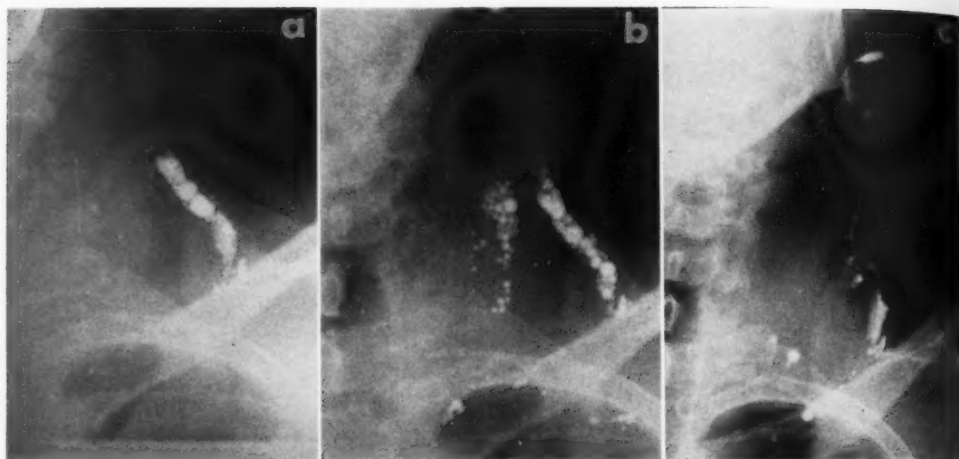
Thirty-one-year-old male with Hodgkin's disease. Roentgenograms demonstrate the passage of the medium into the venous system from an injected lymph node. The globules of contrast material are in the veins. The irregular linear channels represent the lymphatics.
